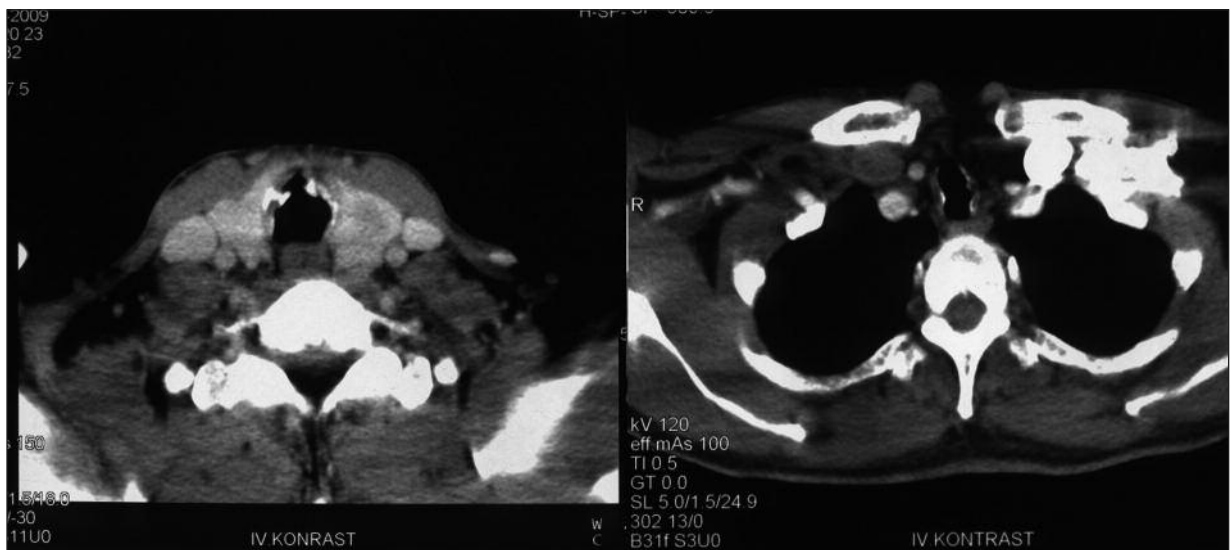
Chest CT scan demonstrated multiple nodular densities along trachea and main carina.
